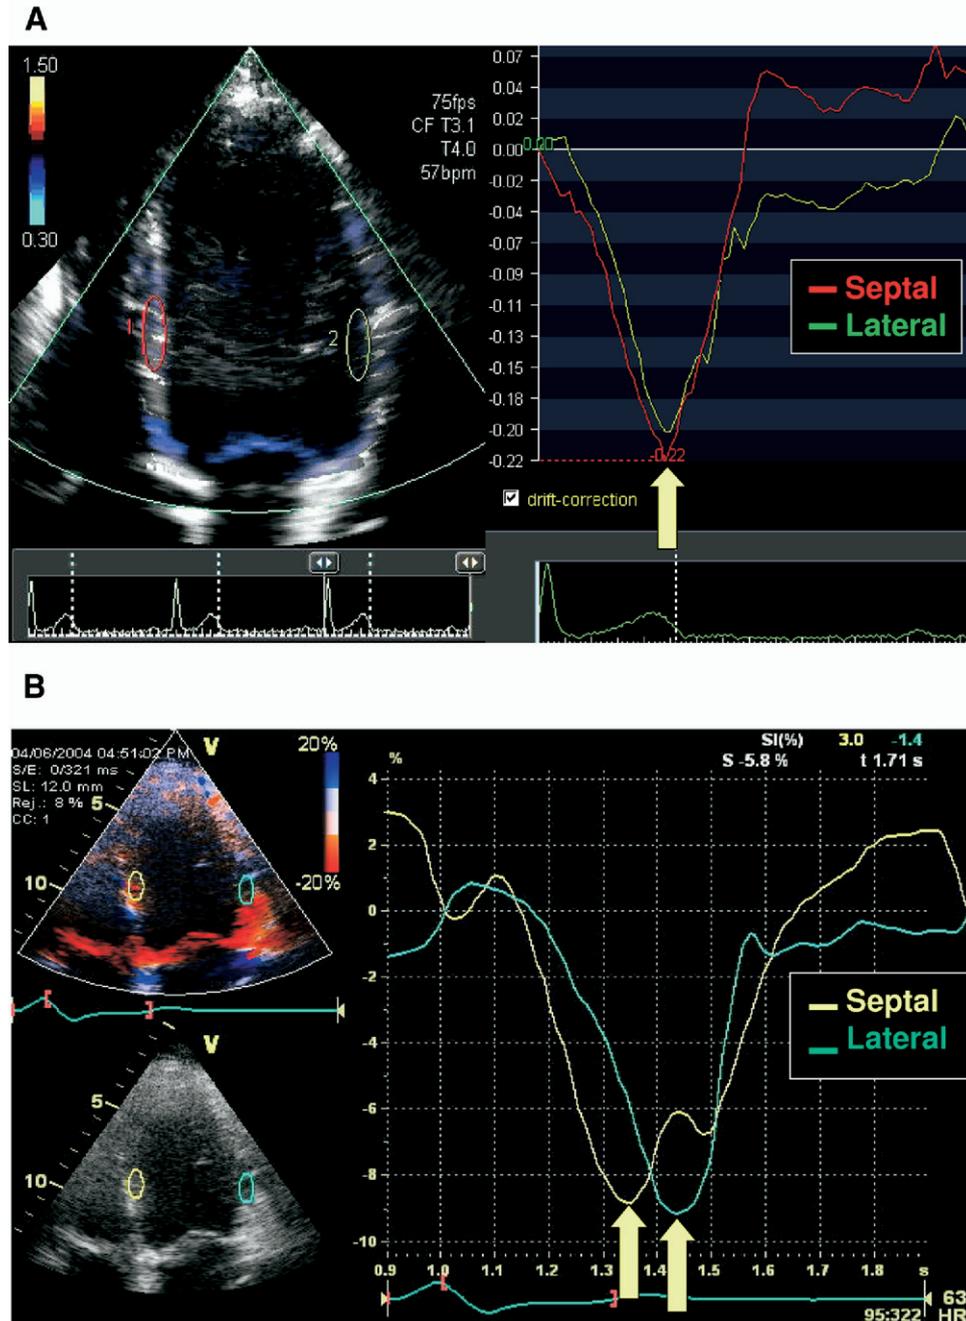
Doppler tissue images demonstrating longitudinal strain in healthy synchronous patient (A) and in patient with left bundle branch block before (B) resynchronization therapy.
